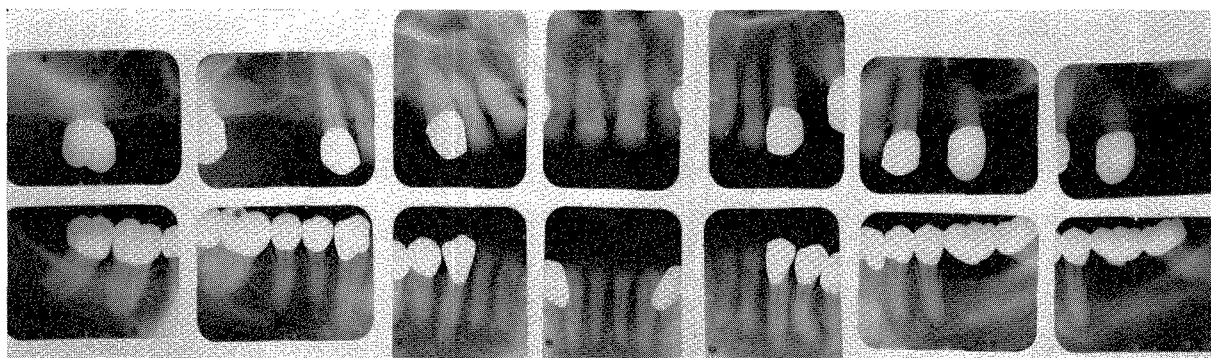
Roentgenograms taken in March, 1946, two years after completion.
